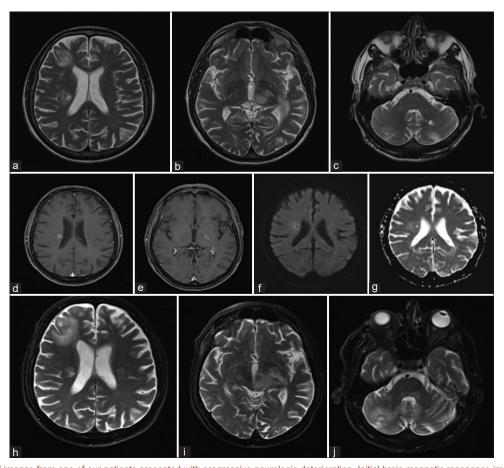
Axial T2W images from one of our patients presented with progressive neurologic deterioration. Initial brain magnetic resonance imaging demonstrating multiple bilateral supratentorial lesions with a low T2 signal intensity rim and involvement of the subcortical U-fibers (a-c). Axial gadolinium-enhanced fat-saturated T1W images showing nodular and ring enhancement (d and e). Restricted diffusion in the periphery of the lesion on axial DWI (b1000) and corresponding ADC map (f and g). Noticeable progression of the disease on follow-up axial T2W images at our institution (h-j)
